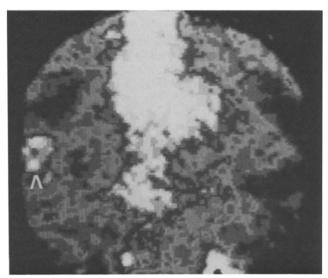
57-Cobalt-bleomycin scintigraphy in a patient with breast cancer. Anterior view of the thorax acquired 1 h after intravenous administration of the radiocompound. A high tumour uptake of 57-cobalt-bleomycin is clearly visible at the right breast (arrowhead). Blood pool activity is observed along the midline.
